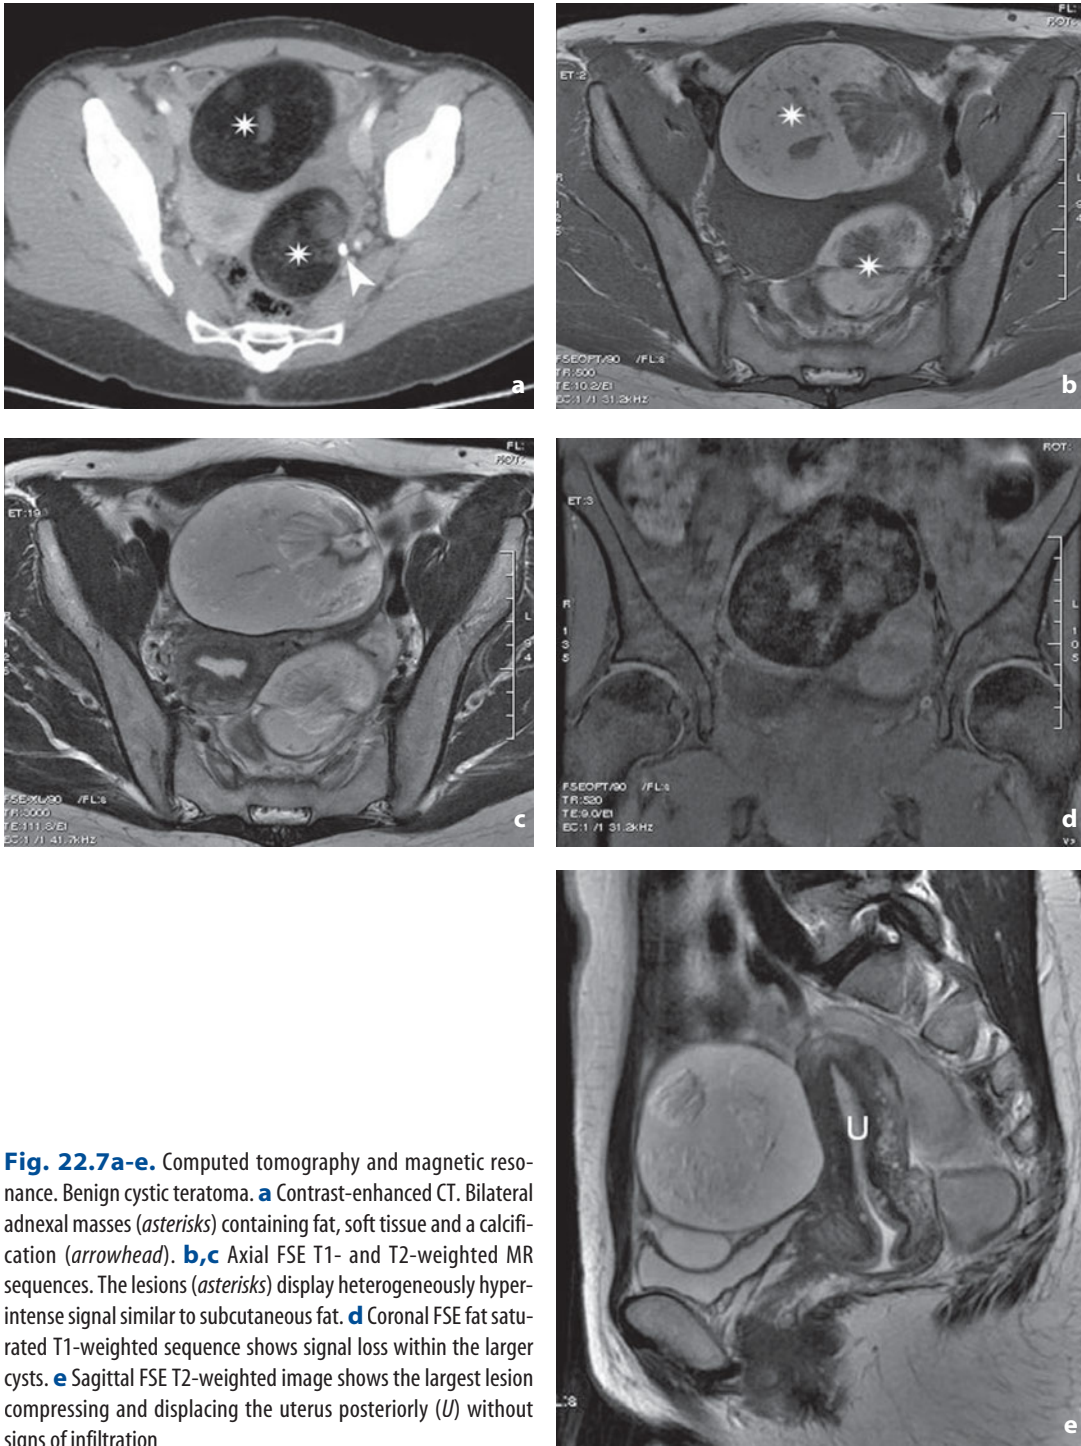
Computed tomography and magnetic resonance. Benign cystic teratoma. a Contrast-enhanced CT. Bilateral adnexal masses (*asterisks*) containing fat, soft tissue and a calcification (*arrowhead*). b,c Axial FSE T1- and T2-weighted MR sequences. The lesions (*asterisks*) display heterogeneously hyperintense signal similar to subcutaneous fat. d Coronal FSE fat saturated T1-weighted sequence shows signal loss within the larger cysts. e Sagittal FSE T2-weighted image shows the largest lesion compressing and displacing the uterus posteriorly (*U*) without signs of infiltration
